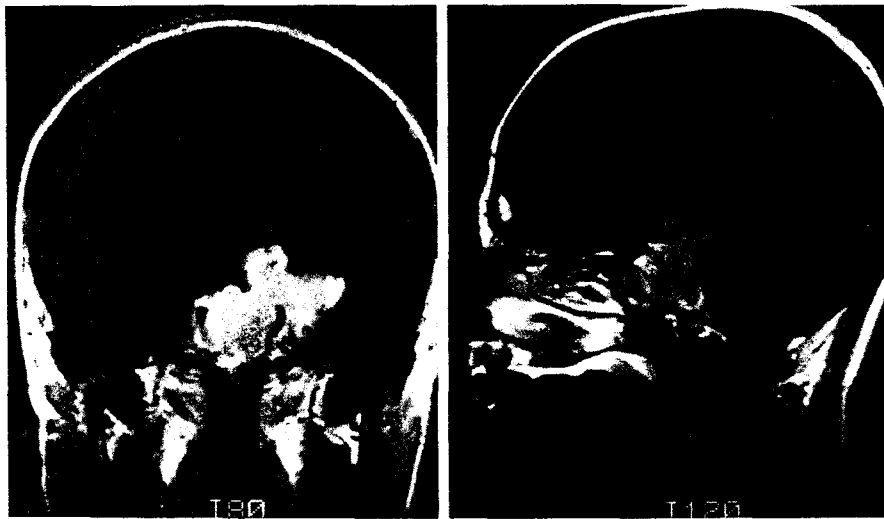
Patient 2. Left, coronal MRI scan with Gd-GTPA showing the lesion filling the pituitary fossa, with encasement of both carotid arteries and extension into the left mesial temporal lobe. Right, sagittal MRI scan with Gd-GTPA demonstrating suprasellar extension of the tumor compressing the left cerebral peduncle.
